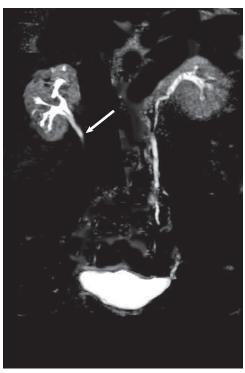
MR urography showing obstructive uropathy. T2-weighted MR image showing a proximal right-sided ureteric ureteral obstruction with an associated mild hydronephrosis. The obstruction was secondary to a ureteral calculus.
